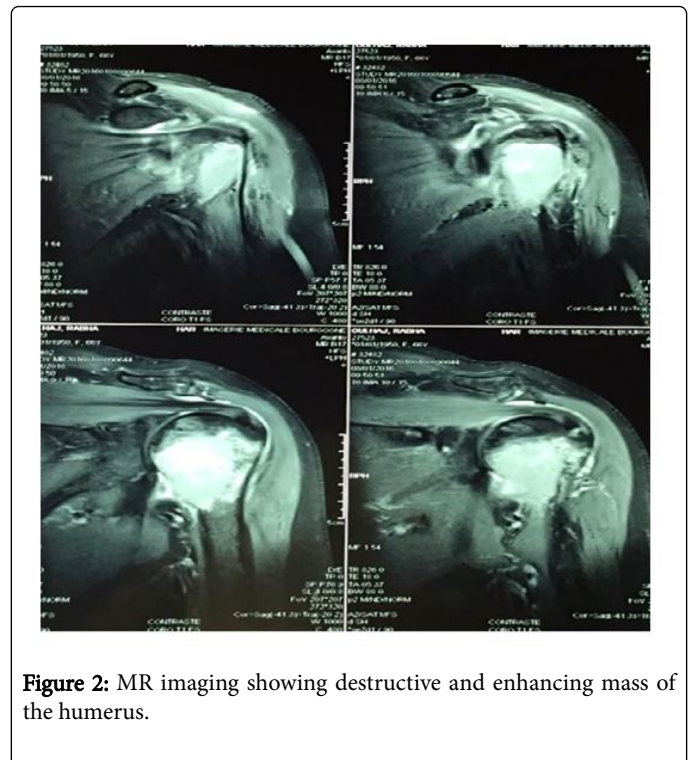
MR imaging showing destructive and enhancing mass of the humerus.
